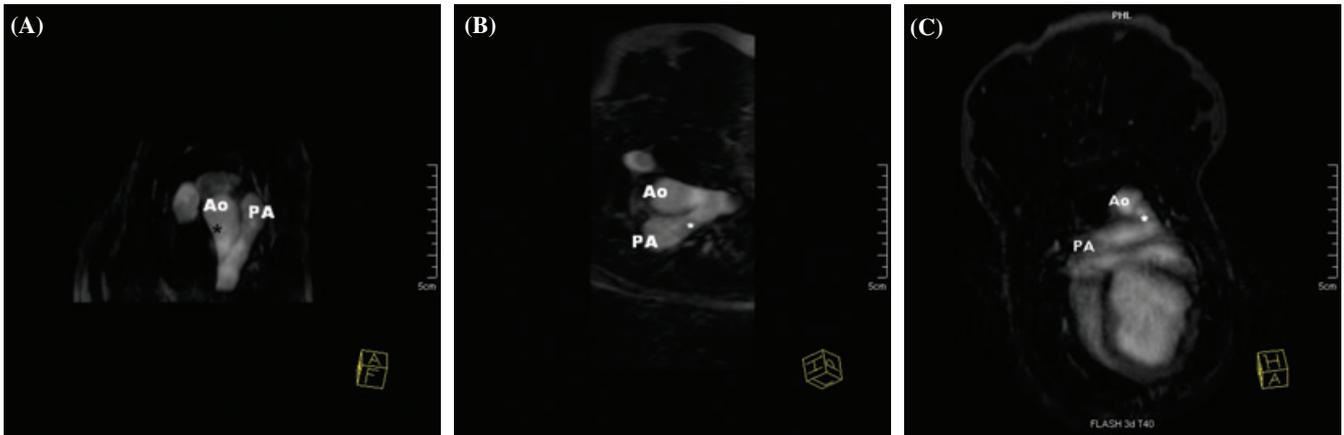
Subvolume maximum intensity projection image derived from the 3D T1-weighted (FLASH) sequence in the axial plane (A) centred at the level of the great vessels showing the aortic origin (Ao) of the ductus (asterisk); PA, pulmonary artery. In the sagittal plane (B), aligned with the long axis of the ductus, its pulmonary artery termination (PA) is clearly seen; Ao, descending aorta. In the dorsal plane (C), the ductus (asterisk) is visualized in its small axis between the descending aorta dorsally (Ao) and the right pulmonary artery (PA) ventrally. Slab thickness, 72 mm, TR/TE, 4.4/1.5 msec; flip angle, 30°; bandwidth, 455 Hz per pixel. The matrix was 137 × 192 (phase encoding from right to left × frequency encoding from ventral to dorsal), FOV of 143 × 191 mm. In-plane spatial resolution was 1 × 1 × 1 mm. One excitation was acquired and acquisition time was 33 sec.
